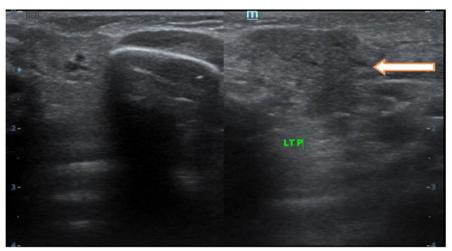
ultrasound picture of enlarged left parotid gland in compare to normal sized right parotid gland
